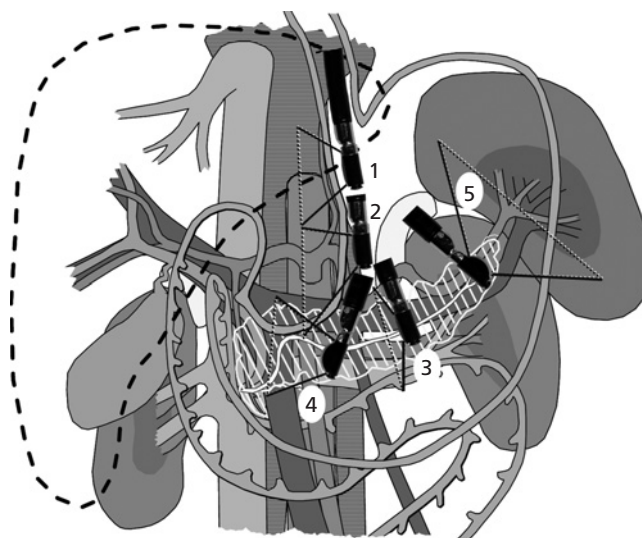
Endosonographic stations in the stomach.
